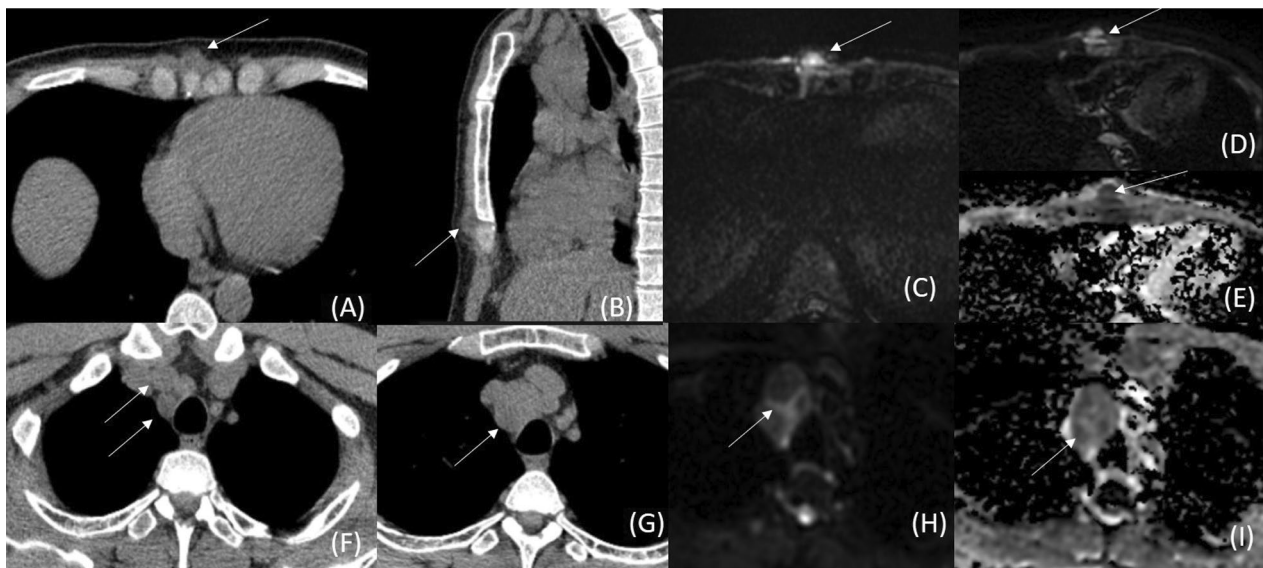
Tubercular chondro-sternal arthritis with necrotic mediastinal lymphadenopathy. CT images of a 41-year-old male show joint widening and effusion in right 6th chondro-sternal joint with collection extending into subcutaneous plane (white arrow in A, B), MRI shows hyperintense collection on STIR (C) with diffusion restriction on DWI (D) and ADC (E). CT images show multiple enlarged mediastinal lymph nodes (arrows in F, G), MRI shows diffusion restriction in the nodes (arrows in H, I)
